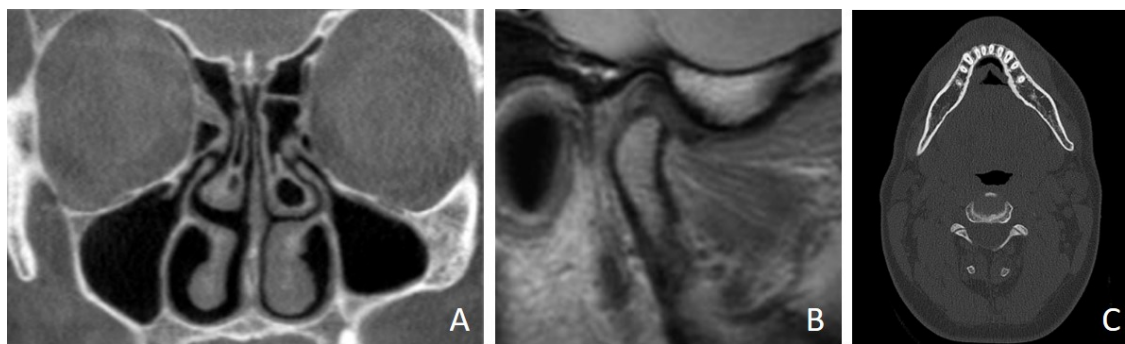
Examples of different imaging modalities applied to the maxillofacial region: CBCT (A), MRI (B) and MSCT (C)
